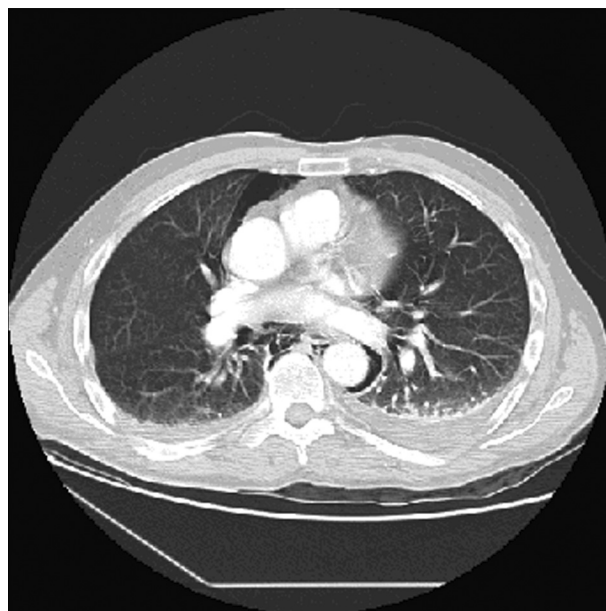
CT showing right pneumothorax, pneumomediastinum and pleurisy.
